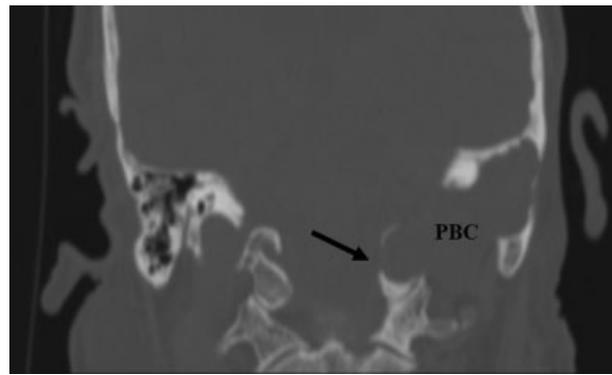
Coronal CT; extensive cholesteatoma eroding part of skull base bone and of the first cervical vertebra (arrow). CT, computed tomography; PBC, petrous bone cholesteatoma.
